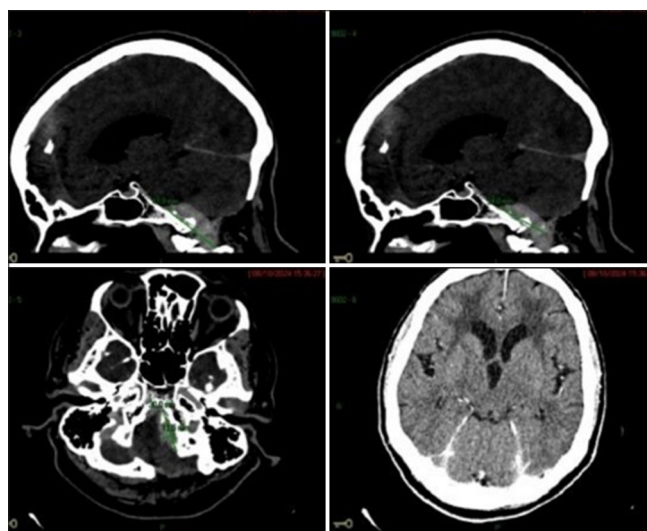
Diagnostic computed tomography study demonstrating dilated ventricles.
